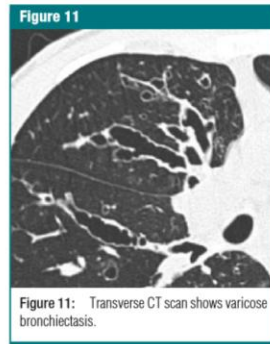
Transverse CT scan shows varicose bronchiectasis.
